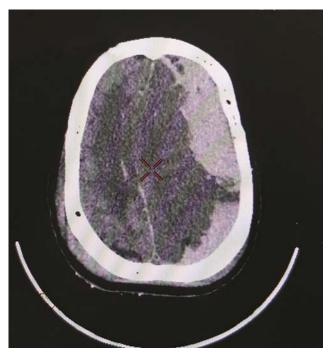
Axial section of noncontrast CT scan brain showing crescent-shaped homogeneously hyperdense extra-axial collection in left frontotemporoparietal region.
